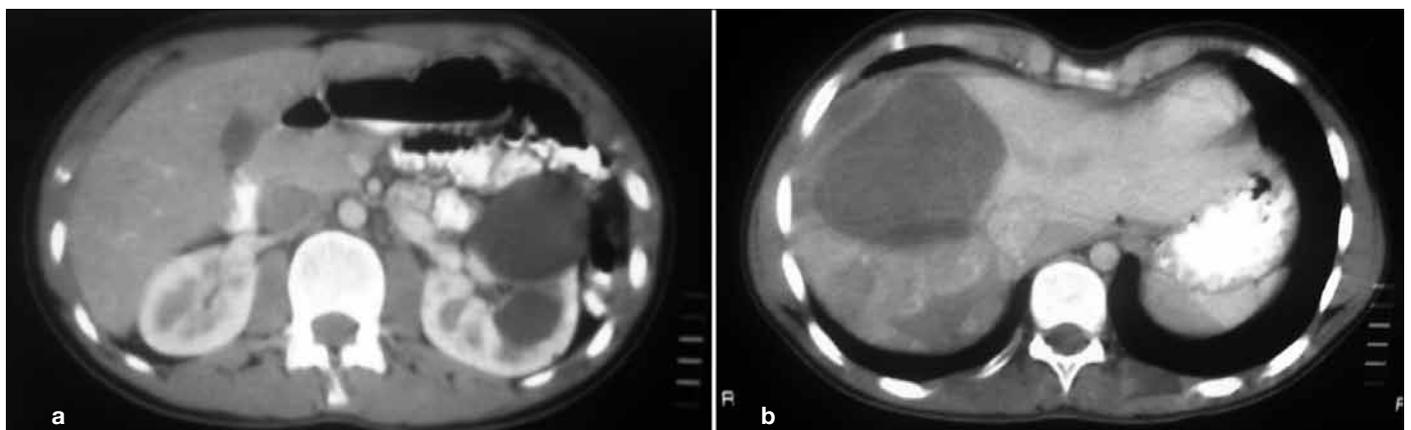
Cystic lesions in kidneys (a) and liver (b) at abdominal CT
